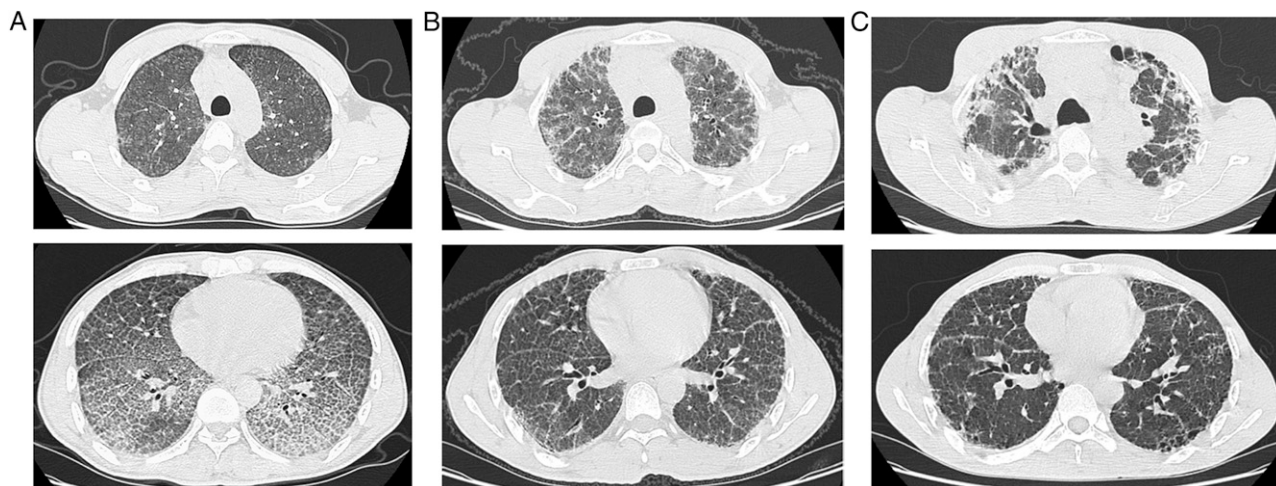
Case C: CT scans of the chest showing progression of disease over 3 years. A, In November 2007 at age 28 years, 4 months after leaving employment. The predominant findings are ground-glass opacities and interlobular septal thickening that in some areas give the appearance of crazy paving. B, In February 2009 at age 29 years, 1.5 years after leaving employment and 10 months after whole-lung lavage. Fibrosis is now apparent. C, In August 2010 at age 31 years, 3 years after leaving employment. Fibrosis has markedly increased. Prominent air spaces anteriorly may be a precursor to the emphysema seen in other cases.
